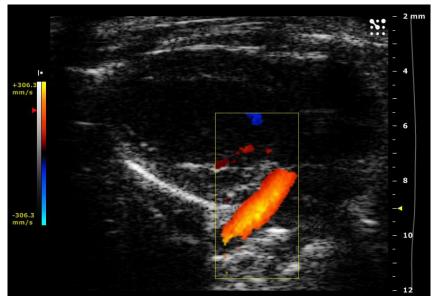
Color Doppler Mode image of the Pulmonary Vein flow entering the Left Atrium.
